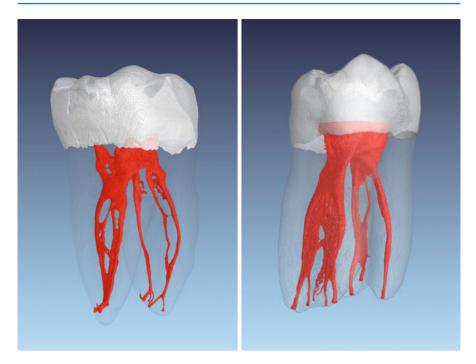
Micro-computed tomography images of two extracted first mandibular molars with complex distal root canal anatomy. Note the various intercanal communications and the severe curvature to the distal aspect in the apical portion (*left*) and six portals of exits (*right*)
